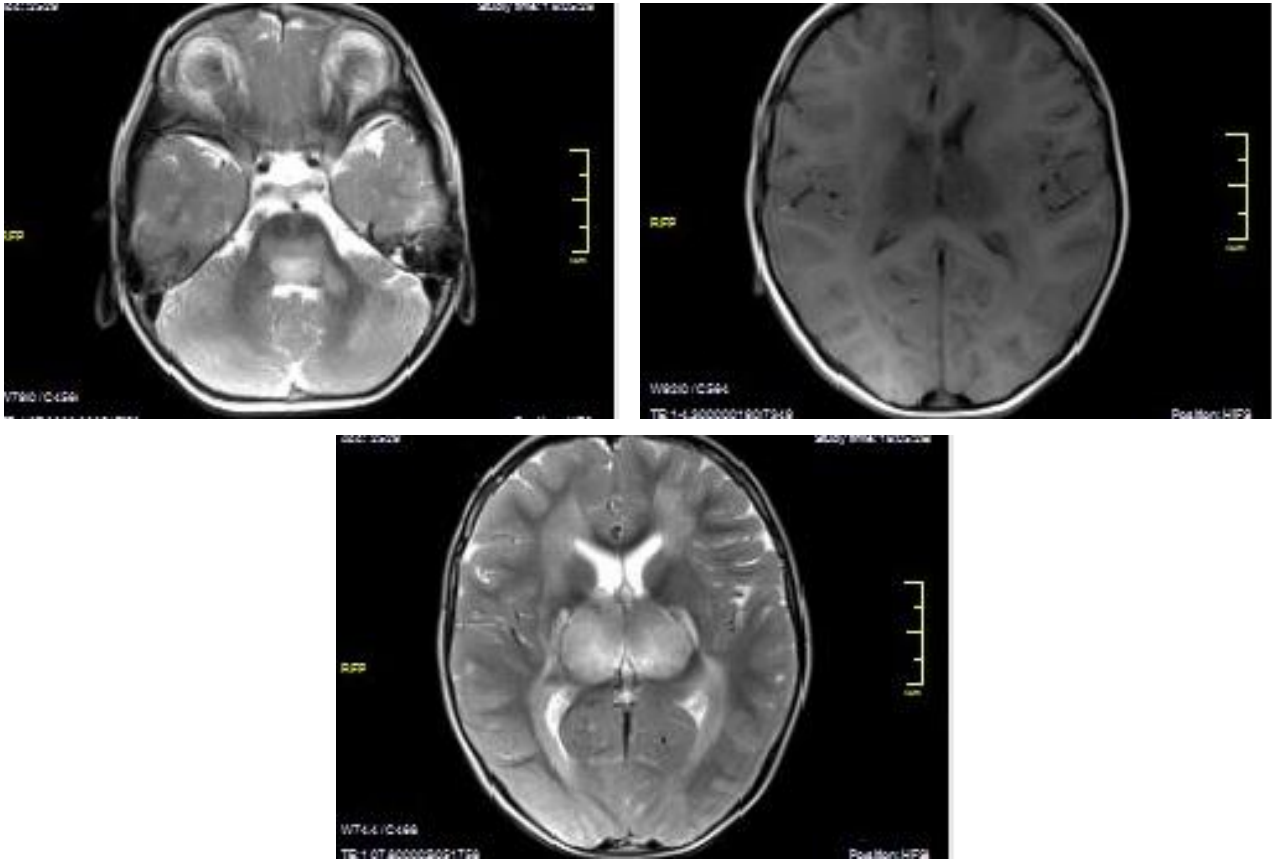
The brainstem lesions are seen hypointense on T1WI (a), hyperintense on T2WI and FLAIR (b,c).
